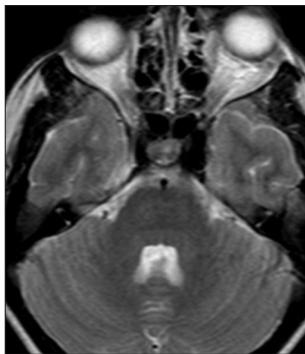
T1-weighted skull magnetic resonance imaging. The left cavernous sinus is dilated due to CCF
